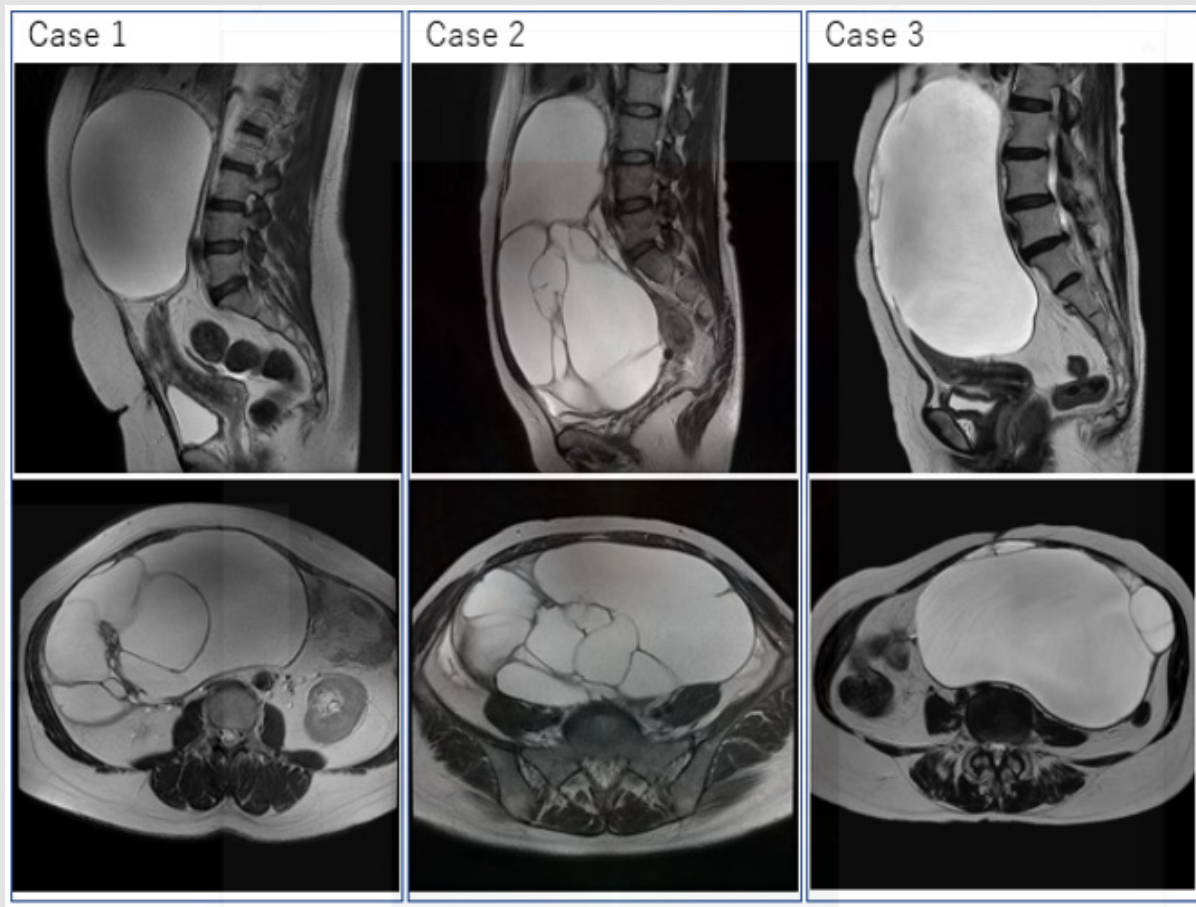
T2-weighted MRI of our cases, sagittal section (upper) and transverse section (lower).
